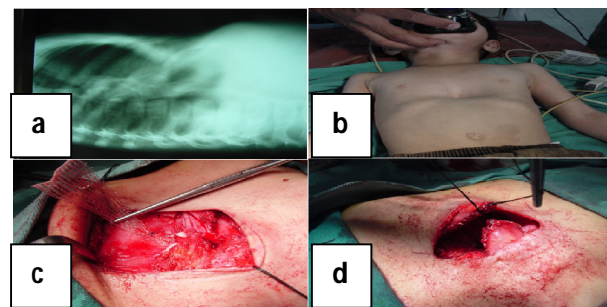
Pectus excavatum (a) Pre op lateral radiograph (b) Anterior view on operating table (c) Prolene mesh strut in place (d) Pectoroplasty.
